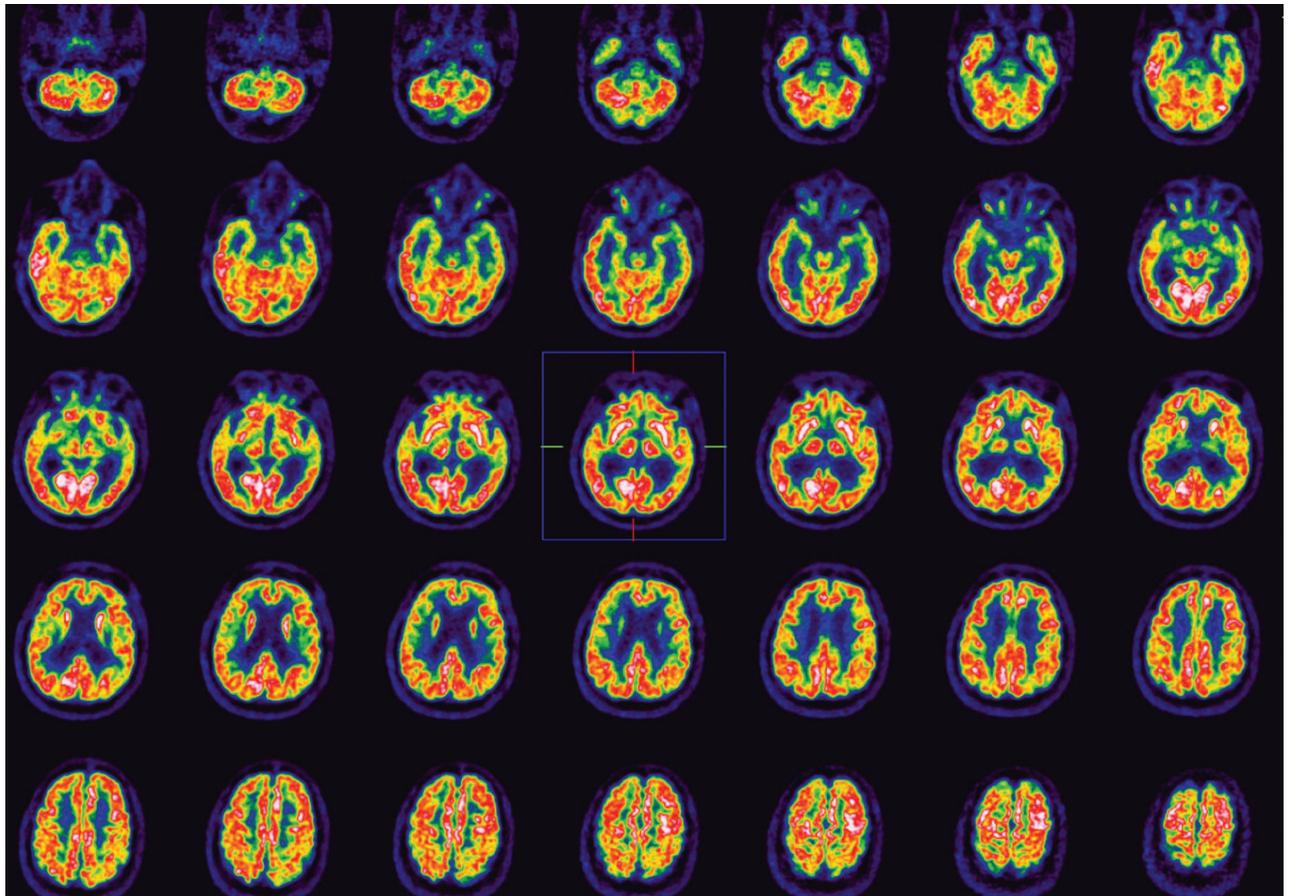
Positron emission tomography (PET) in 2007. Fluorodeoxyglucose (FDG) PET showed hypometabolism in bilateral temporal lobes.
